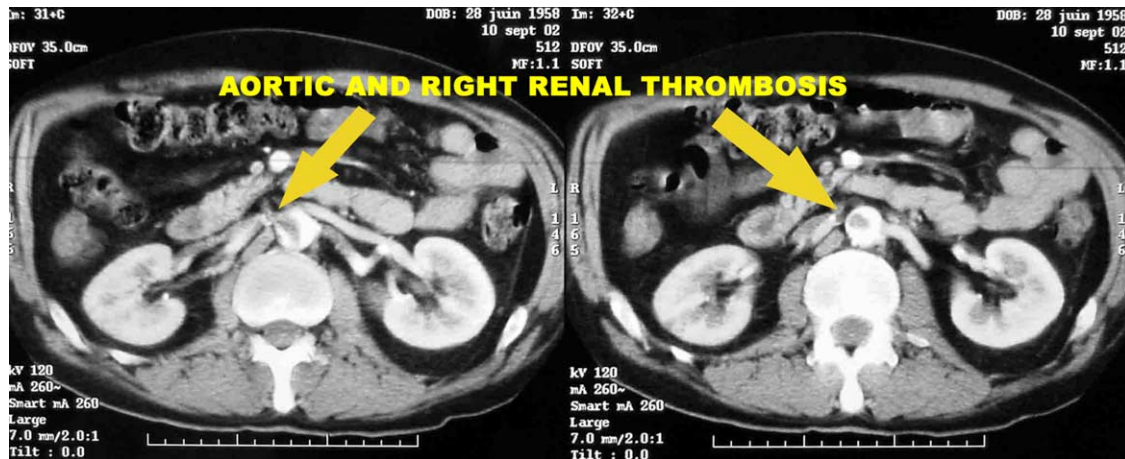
CT scan showing intrarenal aortic thrombosis extending to the right renal artery.
